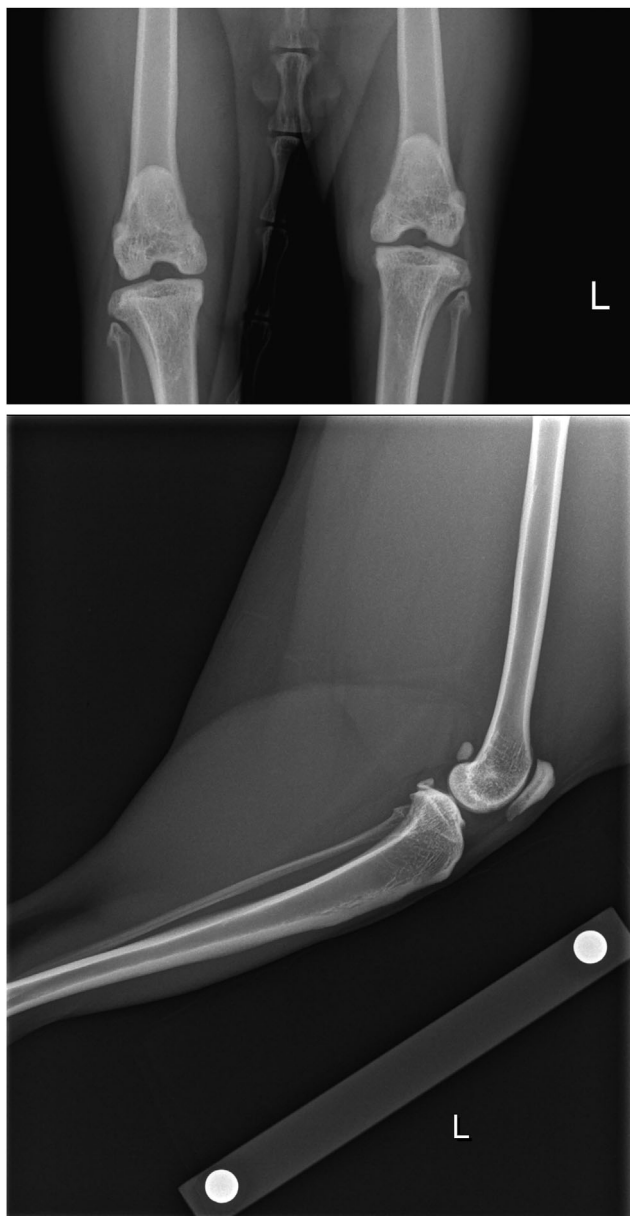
Orthogonal radiographs of the left stifle joint: note the enlarged joint capsule shadow.
